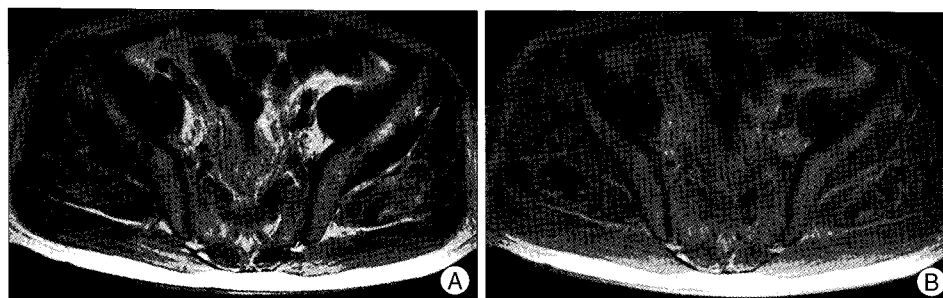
Axial T2-weighted (A) and postcontrast T1-weighted (B) magnetic resonance imaging scans demonstrating hyperintense areas and rim enhancement around hypointense areas in both gluteal muscles, respectively.
